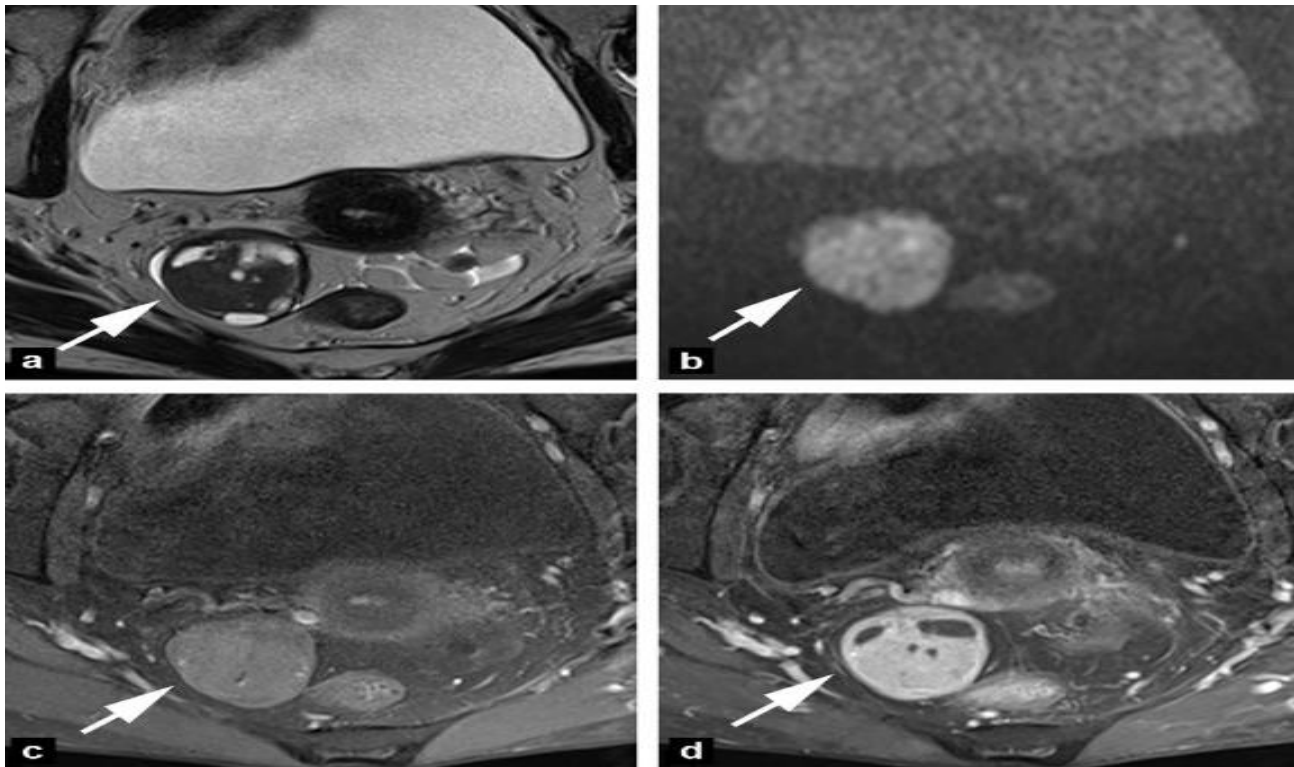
Granulosa tumor of the left ovary (arrow) in a 38-year-old patient (stage pT1a). The mass appears solidokystic with multiple pure fluid compartments and a tissue portion with hypersignal b1000 on the diffusion sequences, enhanced homogeneously. There is no hematic component: a: T2-weighted axial section; b: axial diffusion section b1000; c: axial T1-weighted image with fat suppression; d: axial T1-weighted image with fat suppression and gadolinium injection
